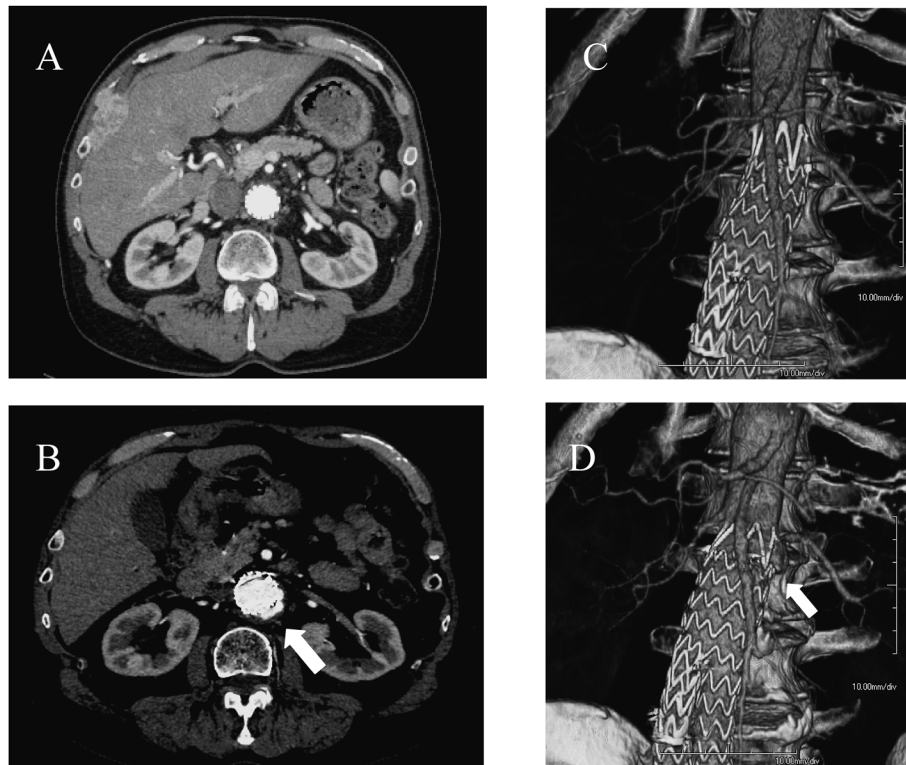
Contrast-enhanced computed tomography after endovascular aortic aneurysm repair (EVAR). (A) Axial plane showing the aorta 15mm below the left renal artery 6 days after EVAR. (B) Axial plane showing the aorta 15mm below the left renal artery 2 years after EVAR. White arrow shows the type I endoleak. The aorta expanded from 26 to 40 mm. (C) Three-dimensional volume-rendering reconstruction showing the juxtarenal aorta 6 days after EVAR. (D) Three-dimensional volume-rendering reconstruction showing the juxtarenal aorta 2 years after EVAR. White arrow shows the migration of the stent-graft.
